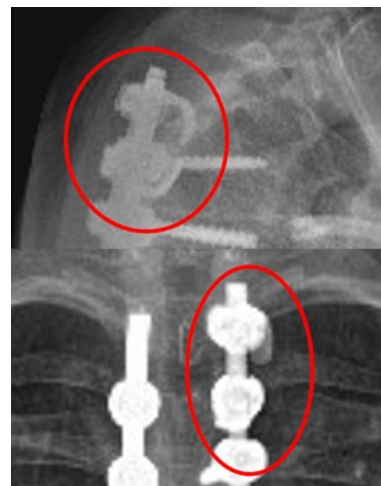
Sagittal and coronal radiographs of two transverse process hooks used at the upper instrumented vertebrae in a patient with Scheuermann kyphosis.
